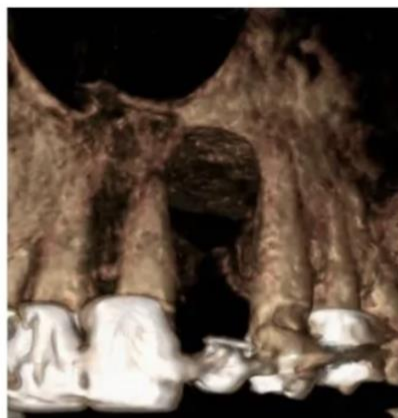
CBCT scan of presentation showing large bony defect.
